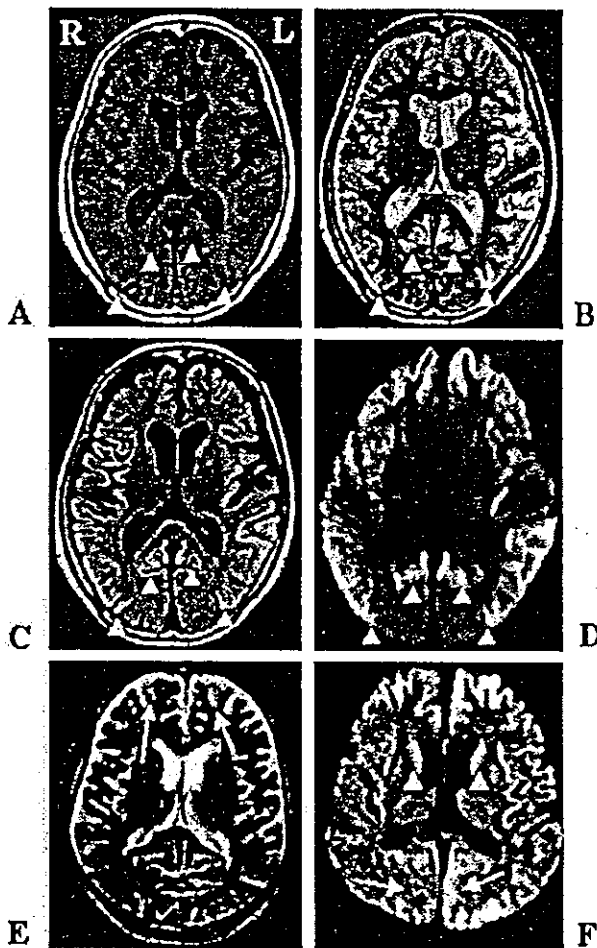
MRI of Patient 1 (A through D) and a patient with sporadic Creutzfeldt-Jakob disease (CJD) (E and F). For Patient 1 (82-year-old woman), the MRI studies were performed 4 months after the onset using 1.5 T MR unit (Magnetom Vision; Siemens, Erlangen, Germany) equipped with a conventional head coil. At this time, she demonstrated only memory disturbance and could perform her daily activities with minimal support. The wide-ranging cortical ribbon is symmetrically depicted as a low-intensity lesion by T1-weighted imaging (A) and as a high-intensity lesion by T2-weighted (B), fluid-attenuated inversion recovery (C), and diffusion-weighted (D) imaging and has a swollen appearance. The basal ganglia are not involved. Characteristically, the medial regions posterior to the parieto-occipital sulcus in the occipital lobes are not involved (arrowheads). The cerebellum was not depicted as an abnormal-intensity lesion (data not shown). For the patient with sporadic CJD with methionine homozygosity at codon 129 (70-year-old man), the MRI studies were performed 2 months after the onset using the same MR unit. At this time, he was totally bedridden and did not respond to any simple orders but opened his eyes when his name was called loudly. He showed myoclonus and startle reflex. The wide-ranging cortical ribbon including the occipital lobe (arrows) and the bilateral caudate heads (arrowheads) are depicted as a high-intensity lesion by diffusion-weighted imaging (F), although T2-weighted imaging examined at the same time demonstrates a high-intensity lesion in only the frontal lobe (arrows).
